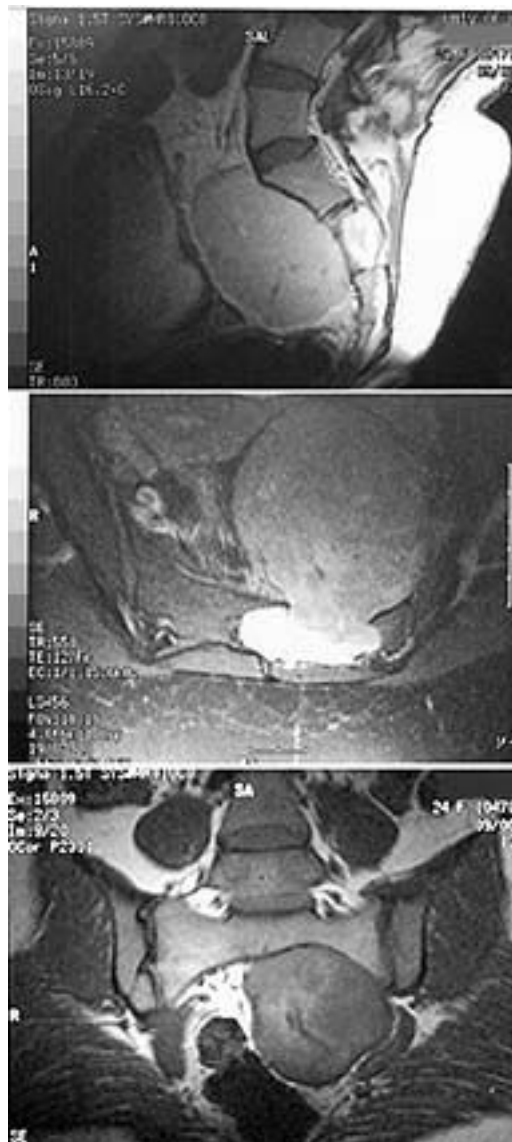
Magnetic resonance images. *Upper:* Contrast-enhanced sagittal image revealing the intra- and presacral components of the tumor. Note the marked enhancement of the intrasacral portion compared with the presacral. *Center:* Axial image demonstrating the same features. *Lower:* Coronal image.
